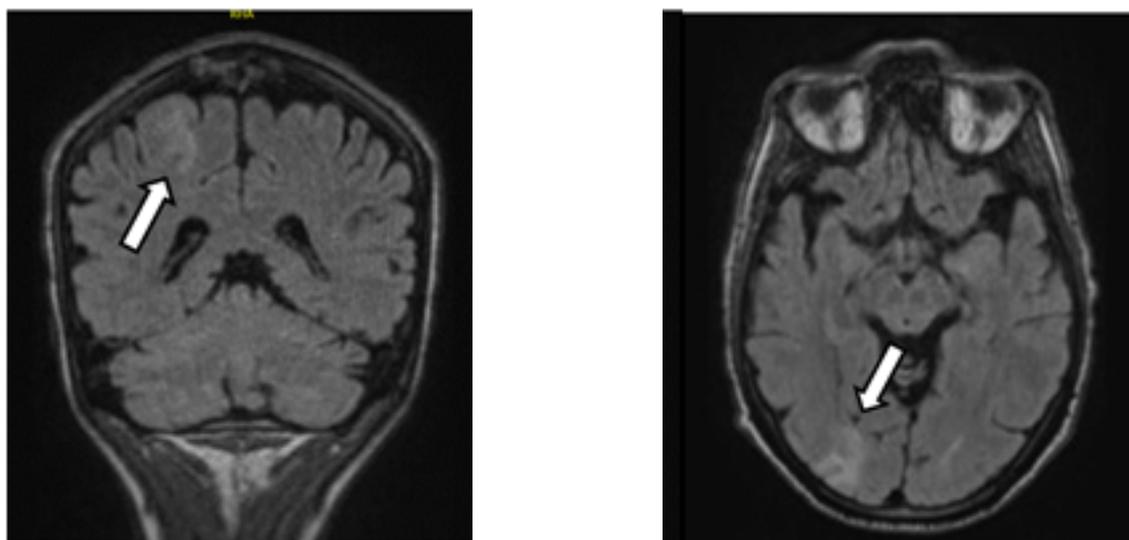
Two examples of epilepsy focus. Restriction of diffusion at the fronto-parietal and right occipital cortical level with anomaly of signal in the form of cortico-subcortical hypersignals on a FLAIR sequence.
